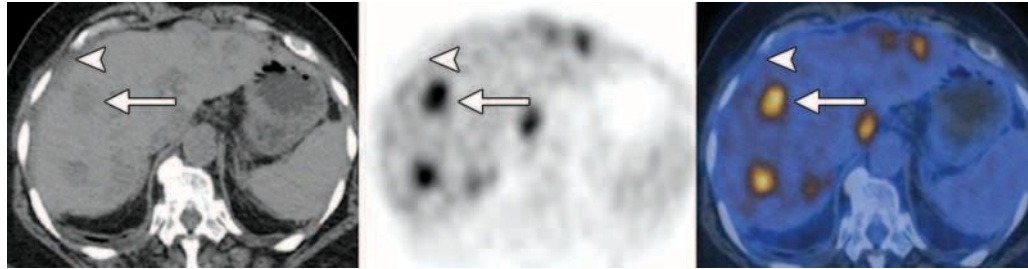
Distant organ metastases in a 73-year-old woman with persistently elevated CA-125 levels and a history of TAH, BSO, radical debulking surgery, and chemotherapy 6 months ago for stage IIIC serous papillary adenocarcinoma. Axial contrast-enhanced CT (left), FDG PET (middle), and fused PET/CT (right) images show multiple hypermetabolic foci throughout the liver that correspond to ill-defined hypointense hepatic masses (arrow), a finding indicative of distant organ metastases. Mild soft-tissue infiltration (arrowhead) is seen along the liver surface with no appreciable FDG uptake, a finding highly suggestive of peritoneal seeding.
